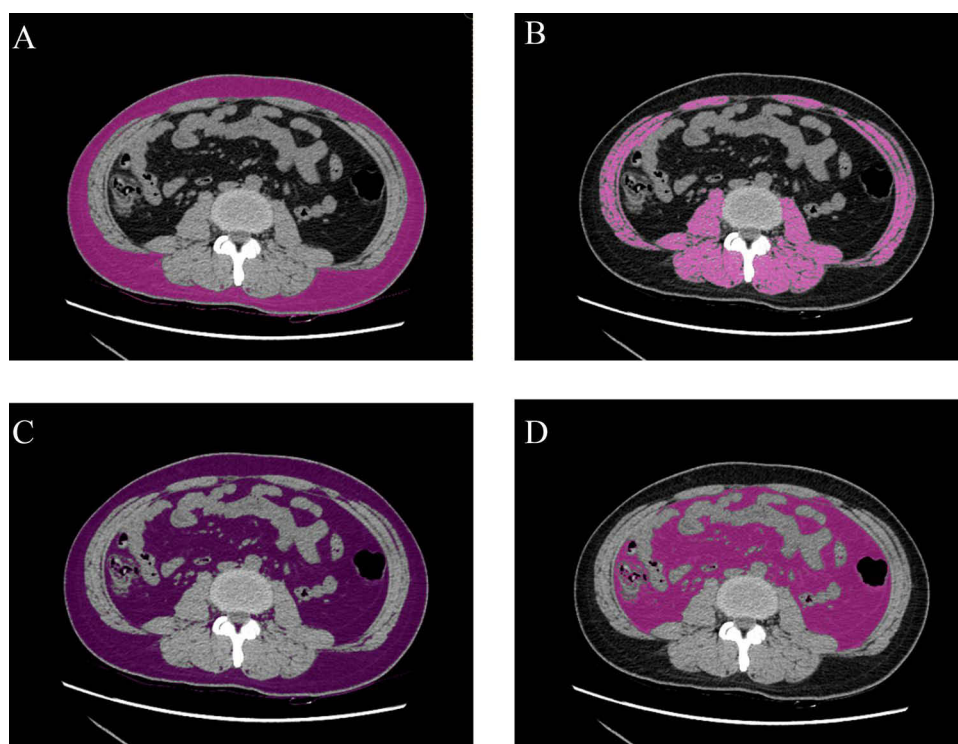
Abdominal CT image post-processing with LIFEx. Subcutaneous adipose tissue (A); Skeletal muscle (B); Total adipose tissue (C); Visceral adipose tissue (D).
